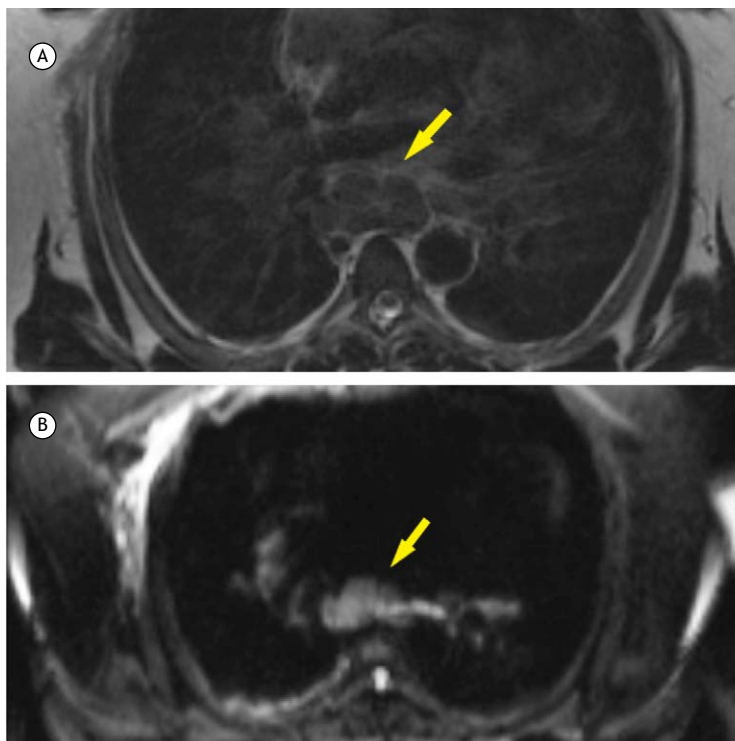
Transverse MRI scans of a 17-year-old man with Hodgkin lymphoma. In A, T2-weighted PROPELLER MRI of an enlarged mediastinal lymph node. In B, apparent diffusion coefficient (ADC) map reconstruction of the lymph node. PROPELLER: periodically rotated overlapping parallel lines with enhanced reconstruction. $ADC = 0.9 \times 10^{-3} \text{ mm}^2/\text{s}$.
